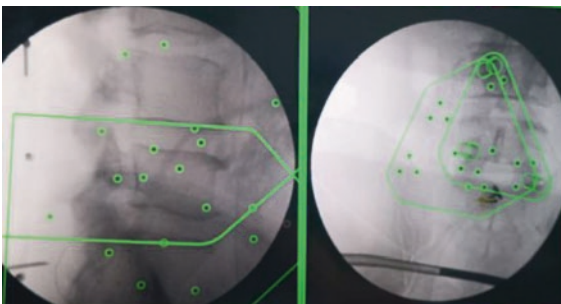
Mapper bridge is put on the low back and standard anteroposterior and lateral X-rays are done to match with the preoperative 3-D CT scans
